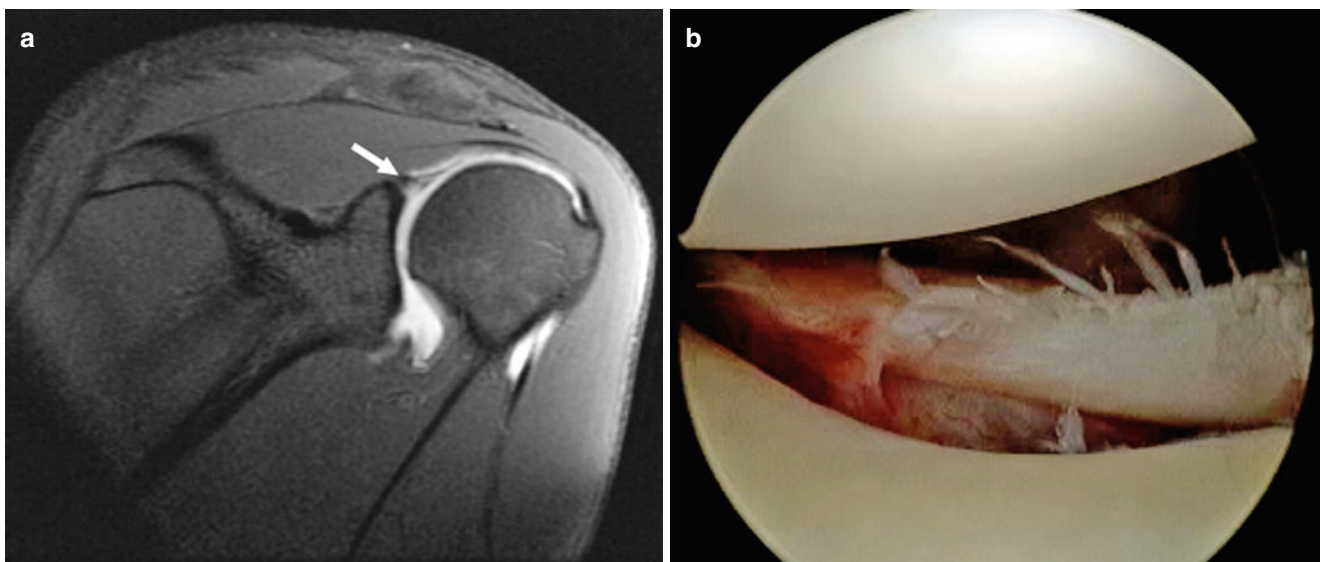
Coronal MRI view (a) and arthroscopic image, *white arrow* shows superior extent of anterior labral tear, which extends inferiorly and torn off anterior glenoid (b) depicting a Bankart lesion
